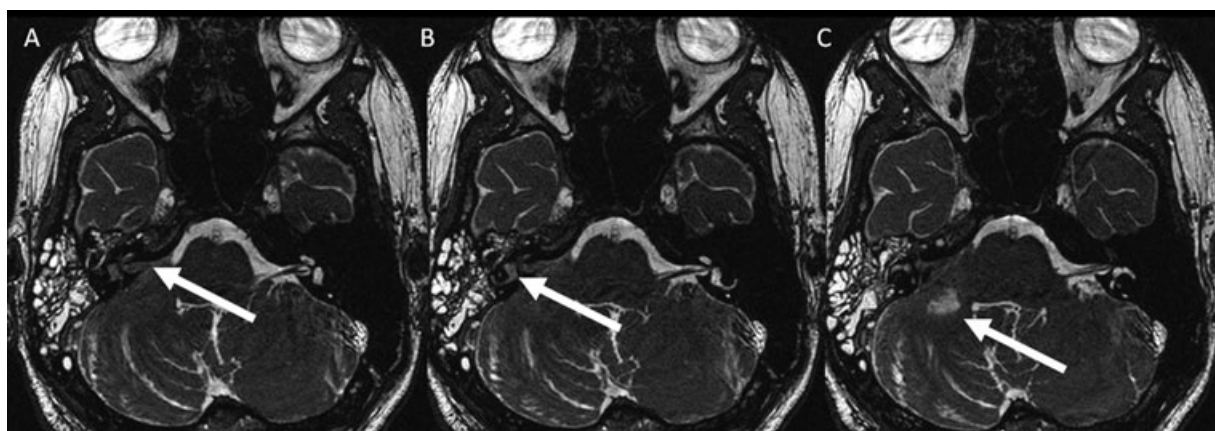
Axial thin sliced heavily T2-weighted MR images (A–C) of the same child as shown in Figure 3 confirm the right sided transverse petrous bone fracture. In addition, MRI shows T2-hypointense blood within the cochlea, vestibulum, semicircular canals, and internal auditory canal (arrows). Moreover, a nonhemorrhagic contusion is identified within the ipsilateral middle cerebellar peduncle (arrow). The right mastoid is completely filled with fluid.
